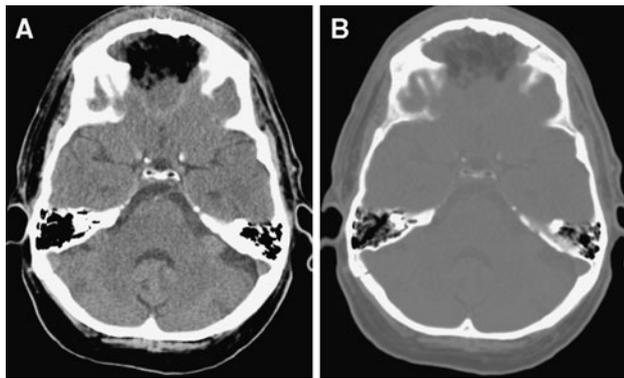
Case 3. A 61-year-old male who underwent bifrontal biorbital craniotomy and anterior skull base resection for squamous cell carcinoma. Soft tissue CT windows demonstrate a very dark frontal collection (a) that can be misdiagnosed for pneumocephalus. Widening of the window demonstrates the internal structure of the fat graft that had been placed at the time of surgery (b)
